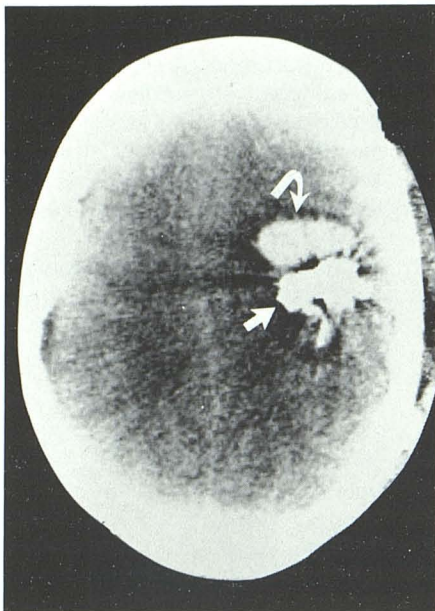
Case 16. Postembolization hemorrhage. Postembolization CT scan. Cast of IBC-2 in AVM nidus (straight arrow). Intracerebral hematoma is anterior to it (curved arrow). Hematoma was not present in preembolization CT scan.
